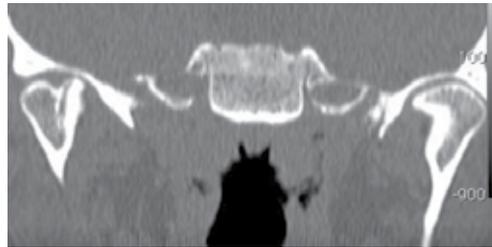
CT of TMJ arthritis (coronal section)
